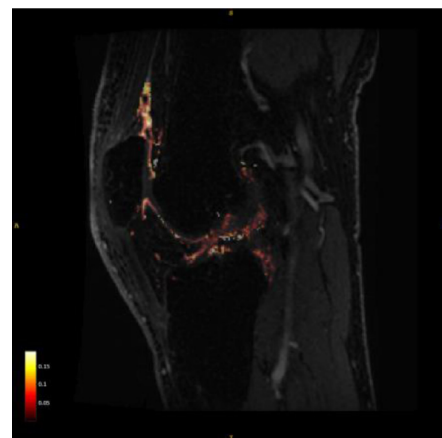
Example of a DCE-MRI image of a patient with knee osteoarthritis, with the Ktrans map [min-1] of the synovium displayed as overlay.
